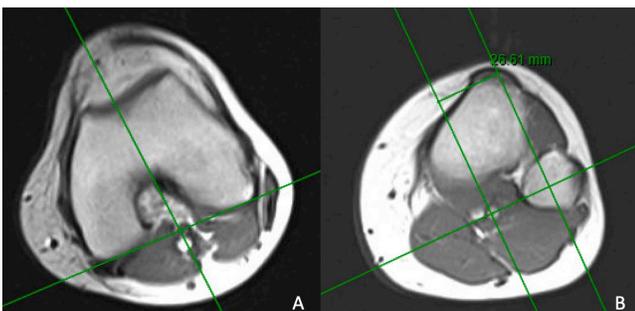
Magnetic resonance image depicting tibial tubercle-trochlear groove (TT-TG) distance, measured in millimeters (mm). (A) The measurement was made in parallel to the axis formed by the posterior femoral condyles. (B) In this example, the TT-TG distance measured 26.61 mm.
